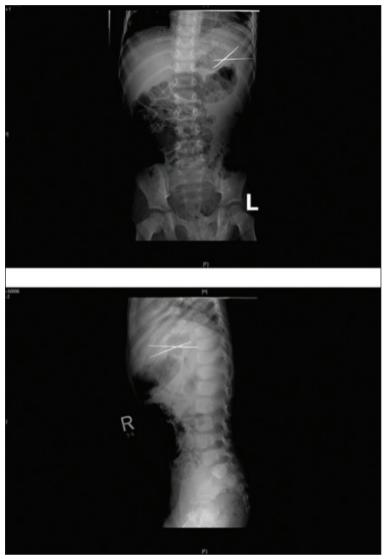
AP and lateral abdominal x-ray showed two radiopaque linear densities projected over the left upper abdomen measuring approximately 5-6cm in length.
